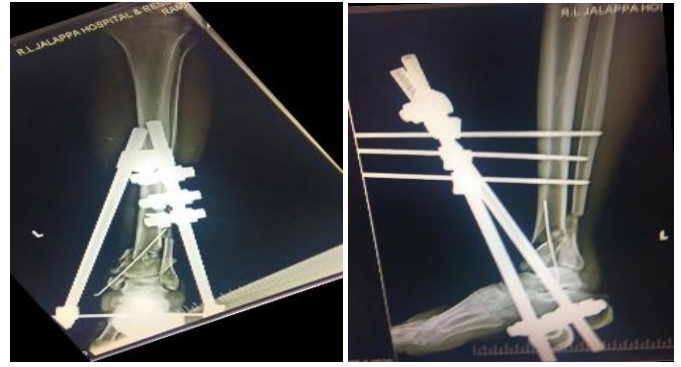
Immediate postop x-ray-AP view Lat view
